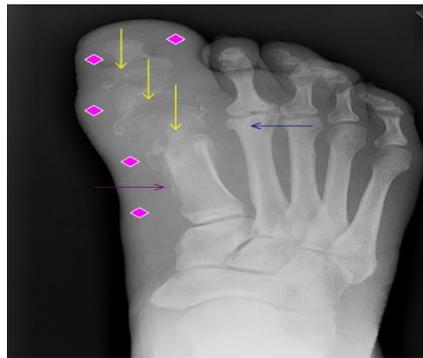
X-ray foot AP view shows: Marked bone lysis(→) of the 1st metatarsal, 1st proximal phalanx and 1st distal phalanx noted. Mild cortical lucency and sclerosis(→) of the medial aspect of the distal 2nd metatarsal. Marked soft tissue swelling(◇) along the medial foot and surrounding the 1st toe joints. Solid periosteal reaction(→) of the 1st metatarsal.
